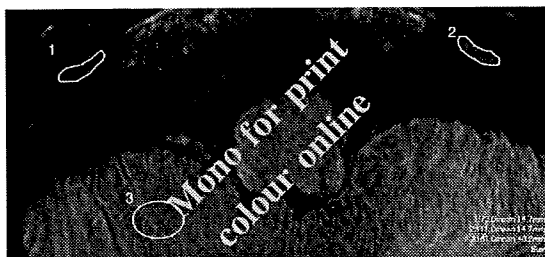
An example of the region of interest (ROI) setting on a contrast-enhanced 3D-FLAIR image. The ROI for the cochlear fluid signal intensity measurement was drawn manually around the basal turn of the cochlea. The circular ROI for the signal intensity measurement of the cerebellum was set in the most artifact-free area of the ipsilateral cerebellum. The signal intensity ratio was calculated as the value shown in the lower right of the figure.
